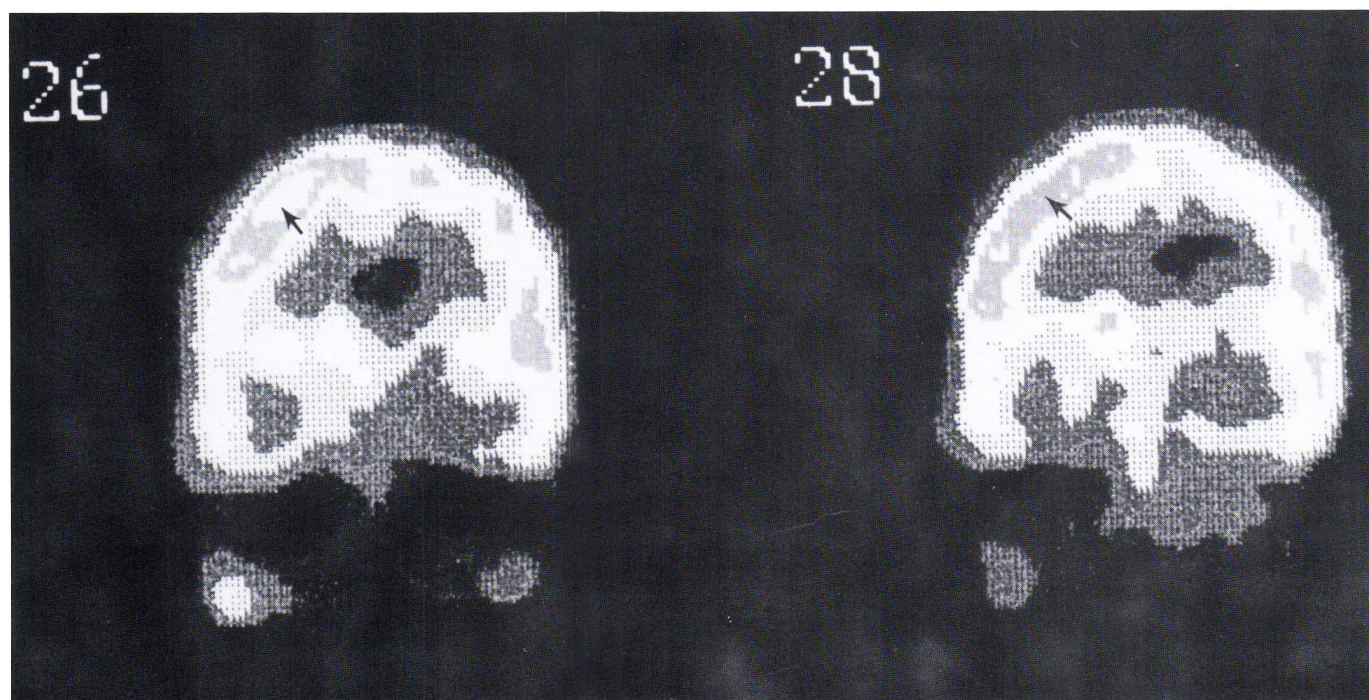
Ictal  $^{99}\text{Tc}$ -HMPAO/SPECT imaging in coronal plane reveals a marked focal increase in cerebral perfusion (arrows) that coincided with a transient increase in seizure activity.
